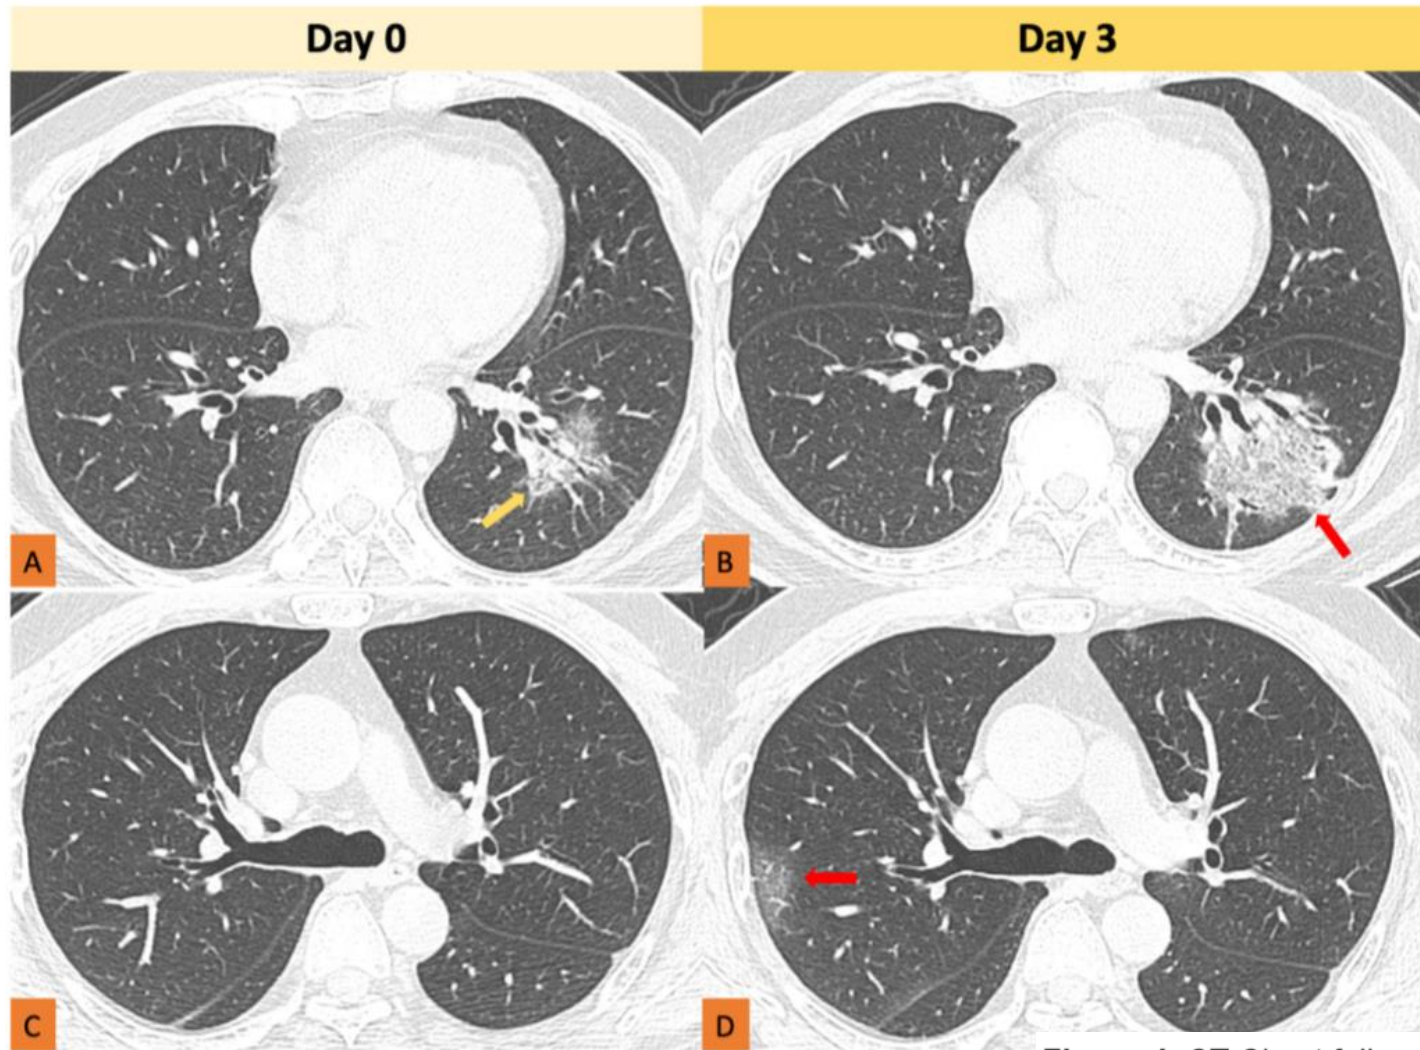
CT Chest follow-up in a patient who had no previous travel to Wuhan, China, but had contact with a patient with confirmed COVID-19 infection. Axial slices from day 0 of presentation to the hospital shows ground-glass opacities in the left lower lobe (image A, arrow), but not in the right upper lobe (image C). Subsequently, 3 days later, the follow-up CT showed increase in the ground glass changes with some peripheral consolidation (reversed halo, image B, arrow) and new ground-glass opacities in the right upper lobe periphery (image D, arrow).
